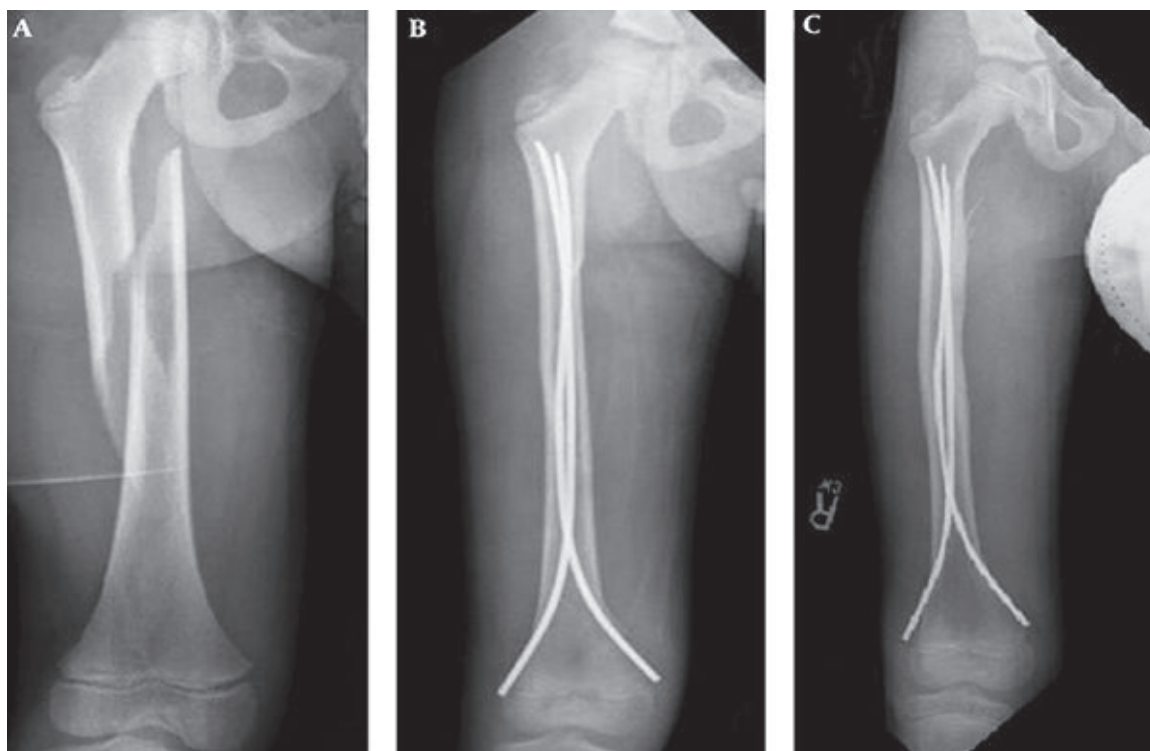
(a) Pre-operative X-ray of fracture shaft (left femur) of 6 yrs old children (b) and (c) Satisfactory fixation of fracture shaft (left femur) of the same children 6 month later.
